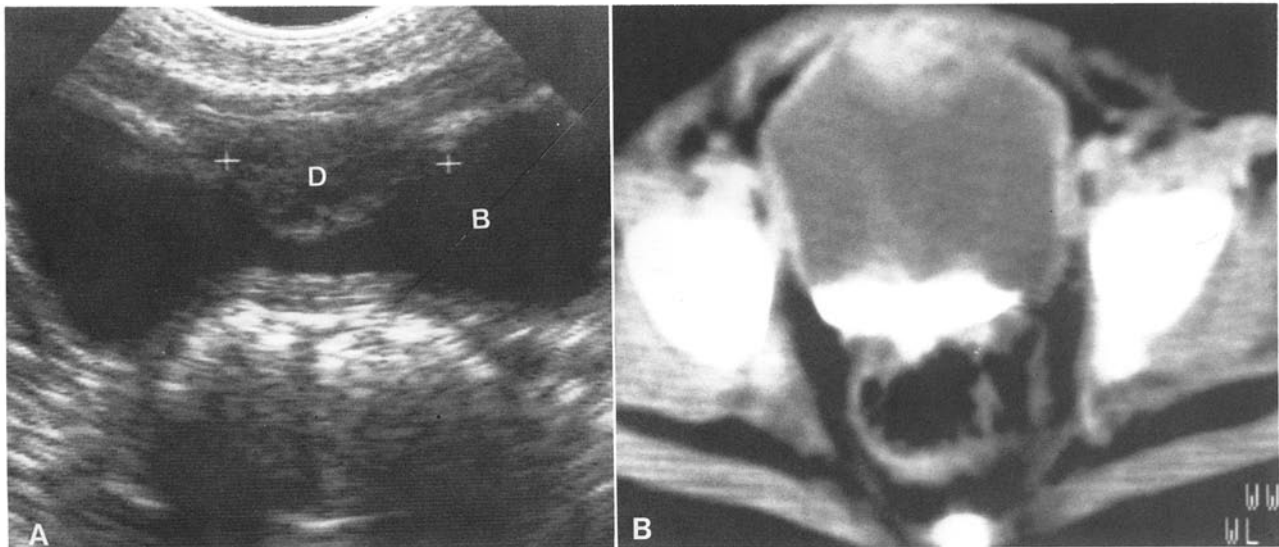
Case 9. Probable dorsal vesicourethral duplication. A Transverse scan of the bladder. *B*, bladder; *D*, duplication. Distance between crosses: 25 mm. B Contrast-enhanced CT scan. Heterogenous mass is present (96 HU) in the anterior bladder wall.
